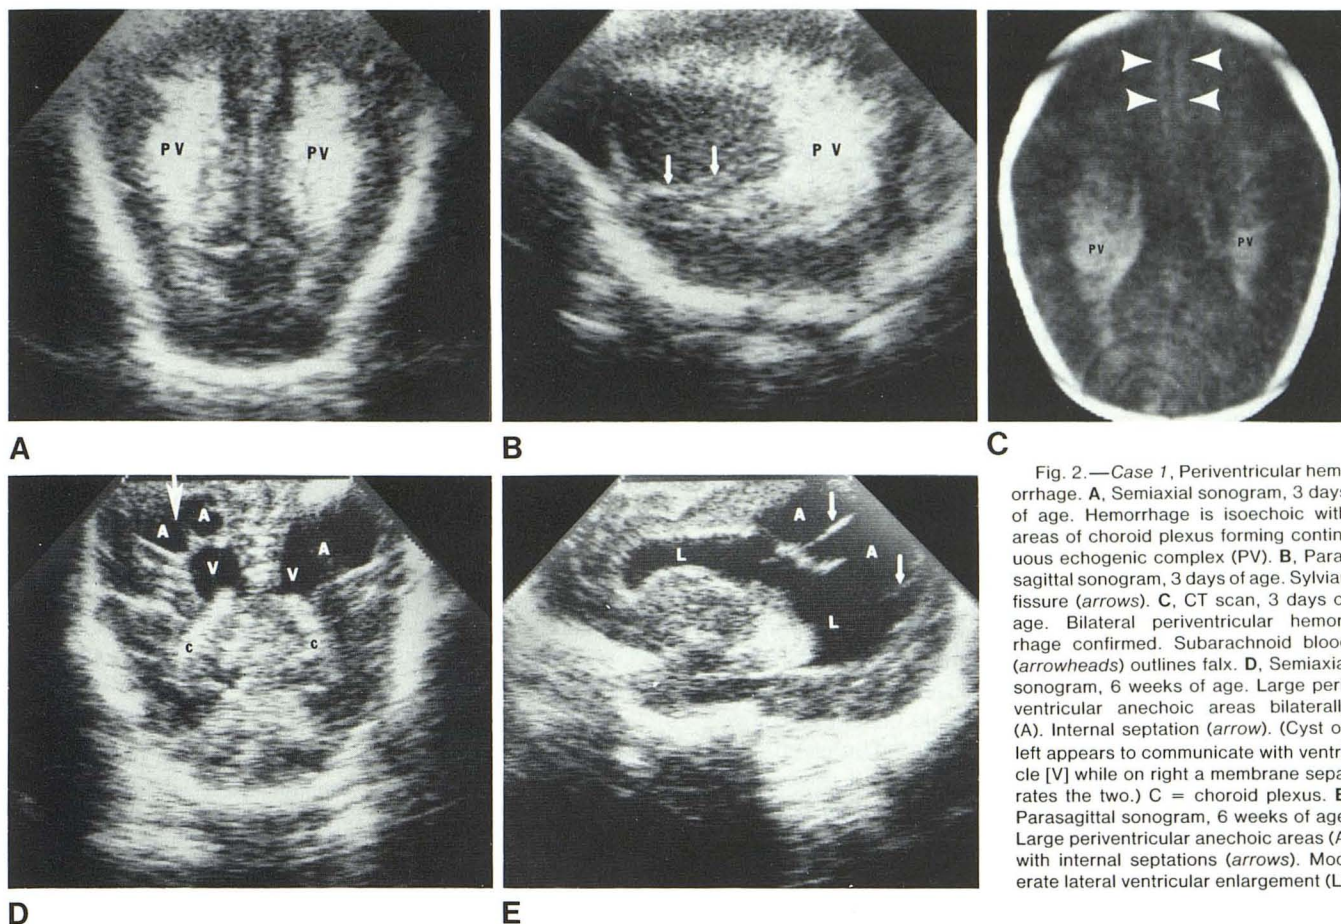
Case 1, Periventricular hemorrhage. A, Semiaxial sonogram, 3 days of age. Hemorrhage is isoechoic with areas of choroid plexus forming continuous echogenic complex (PV). B, Parasagittal sonogram, 3 days of age. Sylvian fissure (arrows). C, CT scan, 3 days of age. Bilateral periventricular hemorrhage confirmed. Subarachnoid blood (arrowheads) outlines falx. D, Semiaxial sonogram, 6 weeks of age. Large periventricular anechoic areas bilaterally (arrowheads) outlines falx. E, Parasagittal sonogram, 6 weeks of age. Large periventricular anechoic areas (A) with internal septations (arrows). Moderate lateral ventricular enlargement (L).
